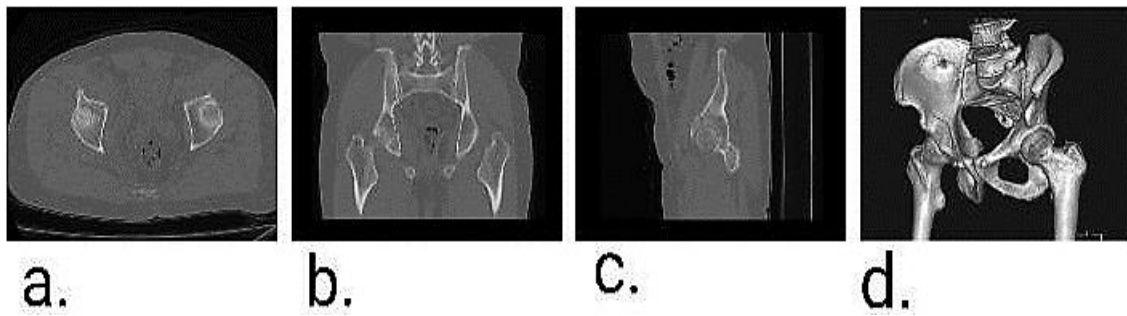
Computed tomography (CT) scan images from our case showing no loose body and minimal articular step-off with an extending fracture line in the cephalad of the anterior column; a) Axial view; b) Coronal view; c) Sagittal view; d) Three-dimensional (3D) CT scan
